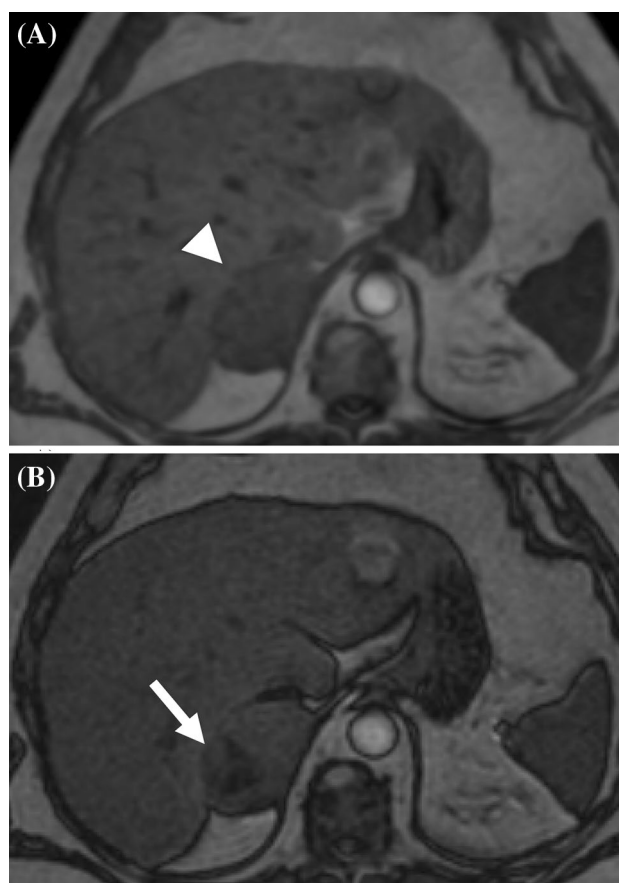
A 46-year-old male patient presenting with hypertension and weight gain. a Axial in-phase MR image shows a hypointense right adrenal mass (white arrowhead). b Axial out-of-phase MR image exhibits non-uniform loss of signal in the adrenal mass (white arrow). Pathology of the mass revealed ACC
